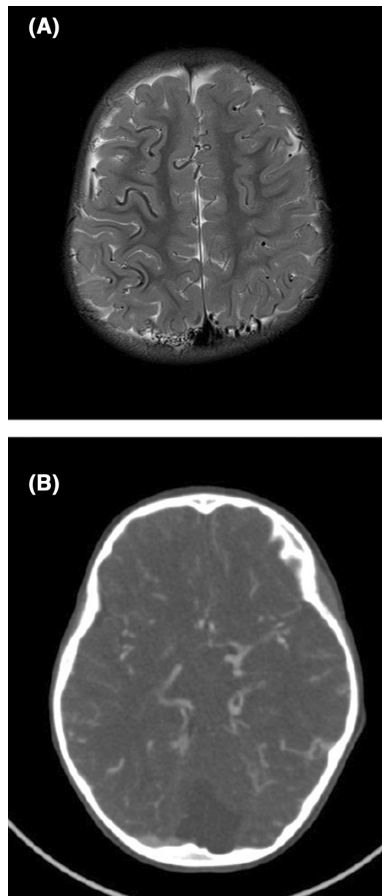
Magnetic resonance imaging (MRI) and brain computed tomography (CT) of a pediatric patient diagnosed with Moyamoya disease (A). The MRI showed that tortuosity and enlargement of the pial vessels were predominantly distributed around the posterior aspect of the superior sagittal sinus, particularly along the right cerebral hemisphere. Some tortuous vessels were also noted within the basal cisterns and posterior fossa. Prominent leptomeningeal vessels along both cerebral hemispheres, with mild prominent cortical vessels. Bilateral periventricular mild white matter volume loss with posterior predominance. Secondary elongation and distortion of the posterior horns were observed (B). CT perfusion revealed decreased cerebral blood flow.
